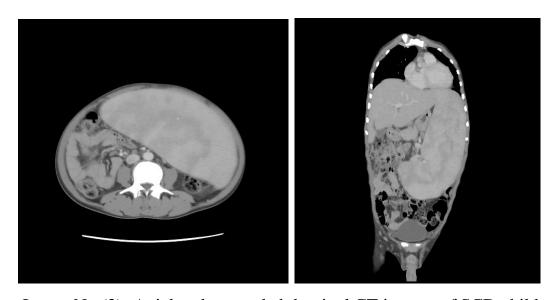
Axial and coronal abdominal CT images of SCD child showing hugely enlarged spleen
